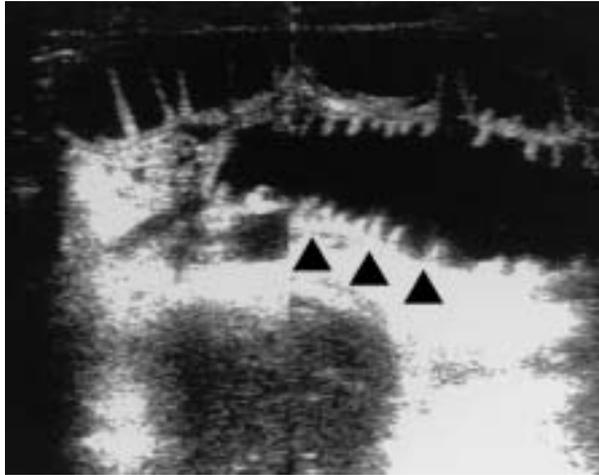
Ultrasonography of simple ileus
